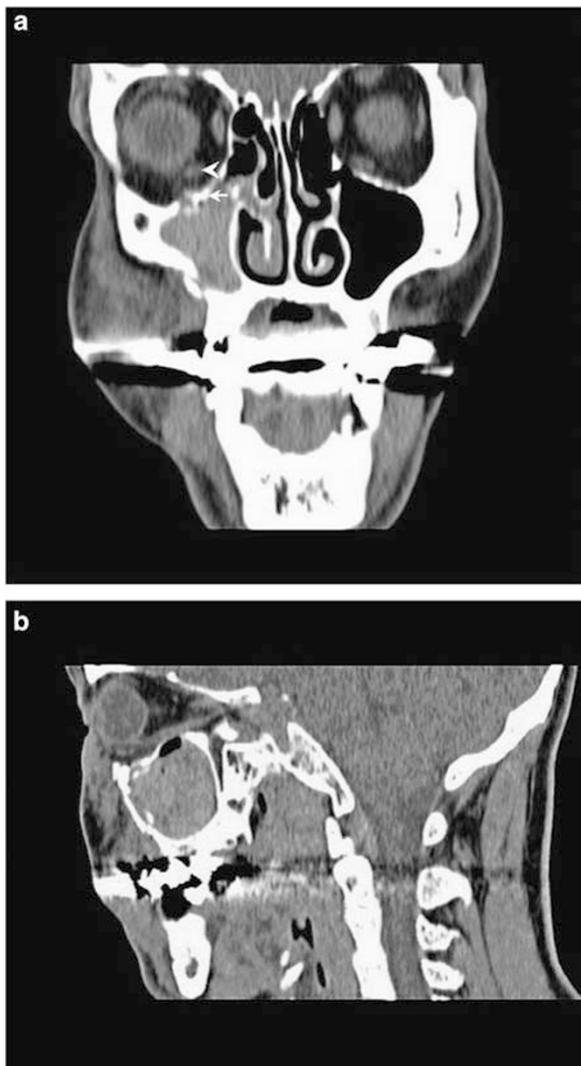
(a) A coronal CT scan of a 39-year-old patient injured from pipe spanner. Fracture of the orbital floor (short arrow) without entrapment of orbital soft tissue or inferior rectus (arrowhead) as well as haemosinus are noted. (b) A sagittal CT scan of the showing a normal course of the inferior rectus muscle within the orbit.
